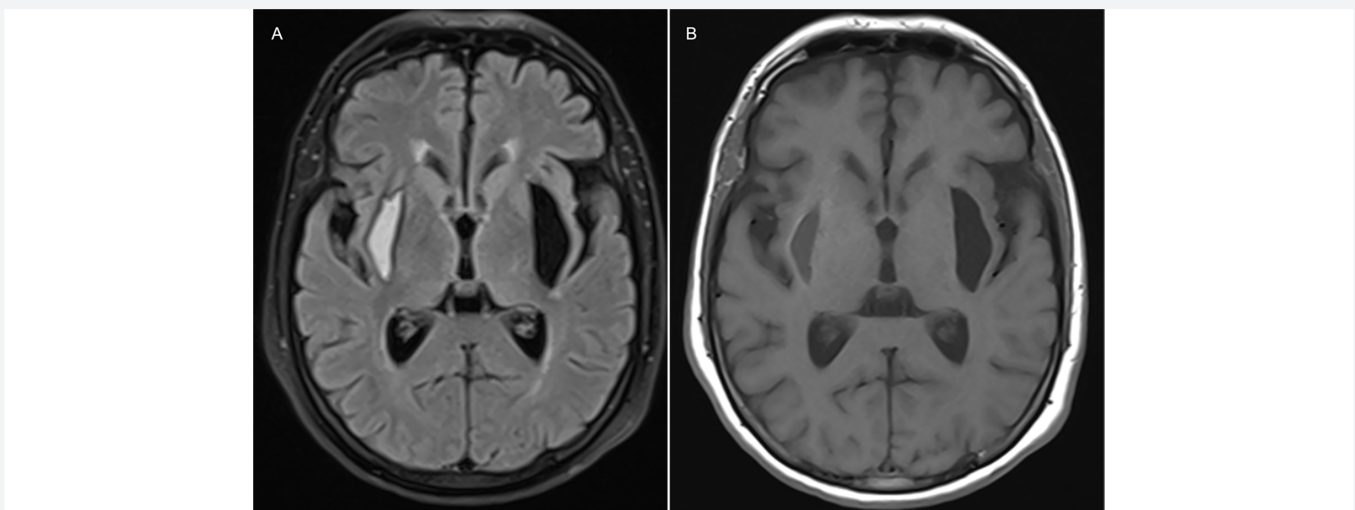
Brain magnetic resonance imaging demonstrated a T2-FLAIR hyperintensity in the right putamen consistent with a subacute hematoma (A), as well as bilateral diffuse T1 hypointensities in the putaminal white matter (B)
